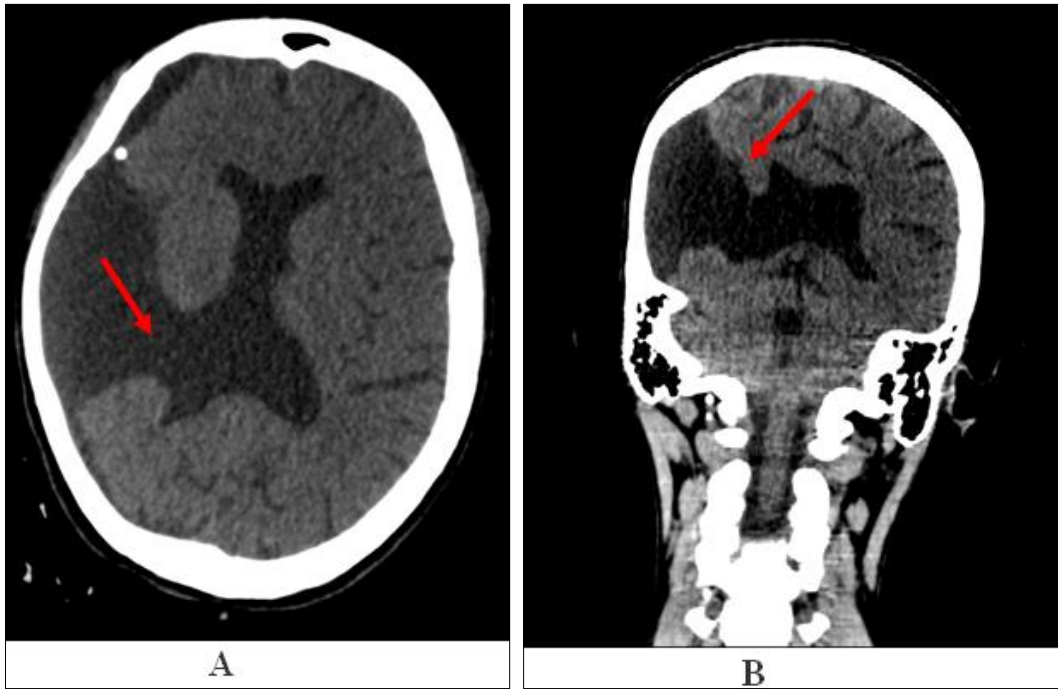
Cerebral CT scan without contrast injection in axial (A) and coronal (B) sections, showing a right parieto-temporal cleft containing cerebrospinal fluid communicating with the ipsilateral lateral ventricle and extending into open fissure subarachnoid spaces, resulting in attraction of the ipsilateral lateral ventricle
